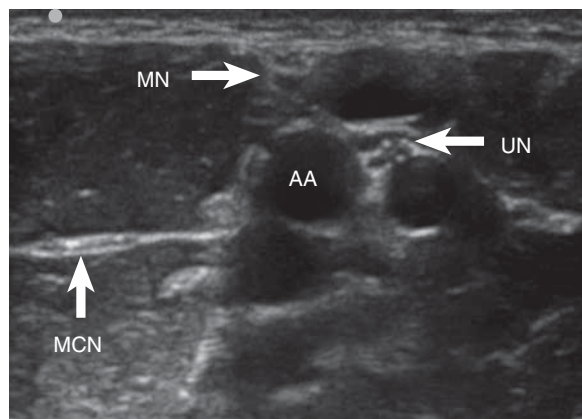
Ultrasound scan of the median (MN), ulnar (UN), and musculocutaneous (MCN) nerves at the axillary level. The musculocutaneous nerve lies between the short head of the biceps muscle (above) and coracobrachialis muscle (below). The radial nerve is not shown with this scanning head position. AA, axillary artery.
